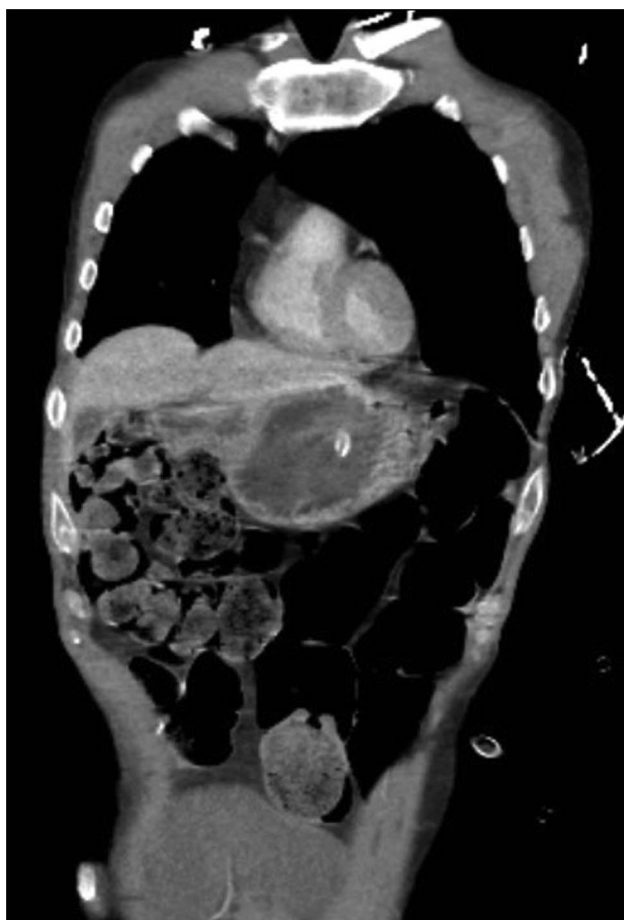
Computed tomography of the abdomen revealing a moderate to large amount of stool in the colon. The bowel is diffusely dilated but no evidence of obstruction.
